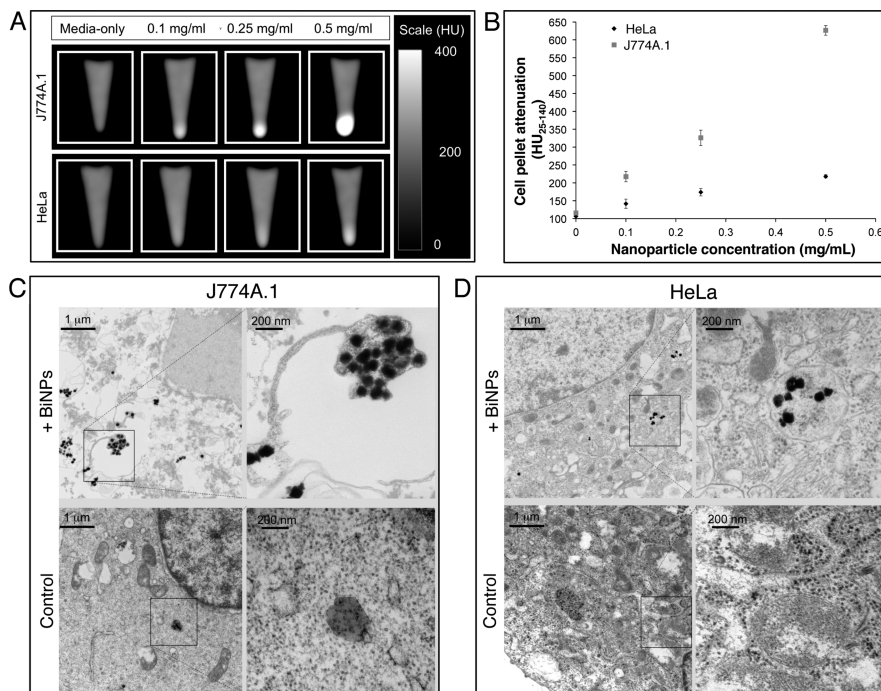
Uptake of BiNPs in model cell lines. (A) CT images of J774A.1 and HeLa cells incubated with BiNPs and formed into pellets. (B) Quantitative analysis of the attenuation in the cell pellets. TEM shows that BiNPs are taken up in endosomal/lysosomal compartments in both J774A.1 (C) and HeLa cells (D).
